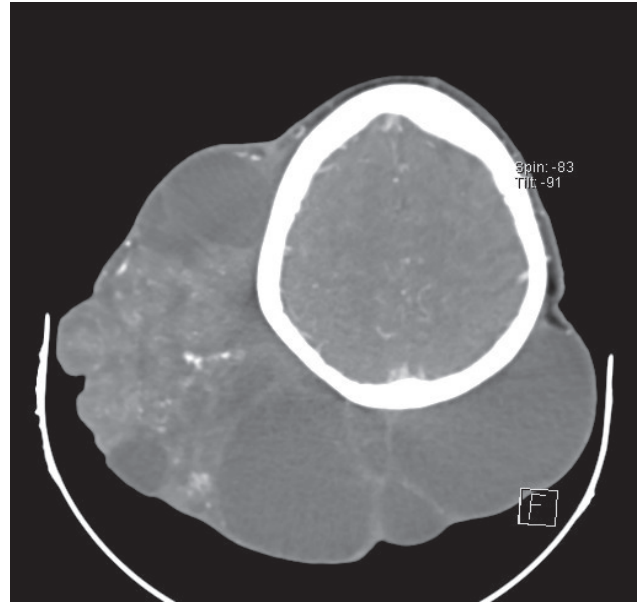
CT scan without bone invasion of the cranial vault
